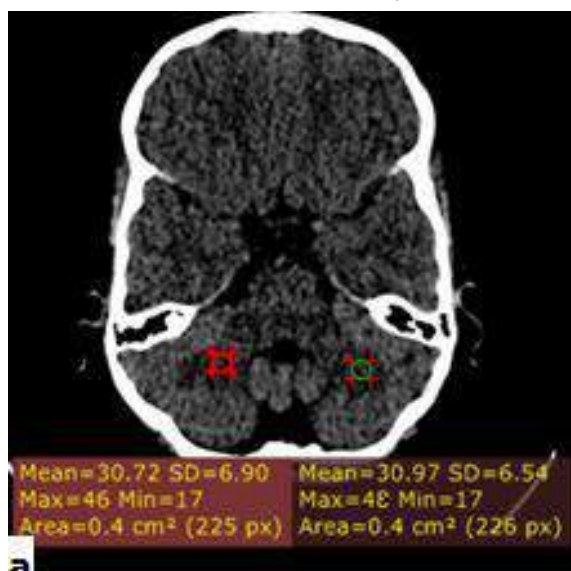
Axial CT image at the level of cerebellar white matter to show the objective analysis using region of interests and measuring the average density.
